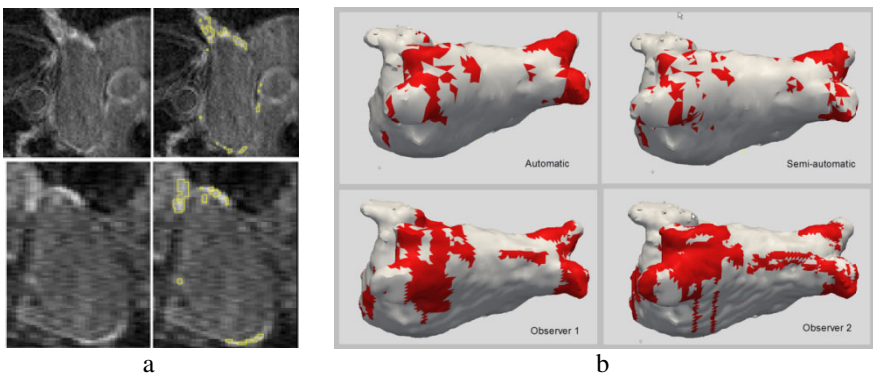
Results from segmentation methods. (a) Automatic segmentations for patient 1 showing 2 example slices from the DE-MRI data; (left) original image data; (right) with segmentation annotations. (b) Surface representations for segmentations results for patient 2 showing automatic, semi-automatic and manual segmentations.
